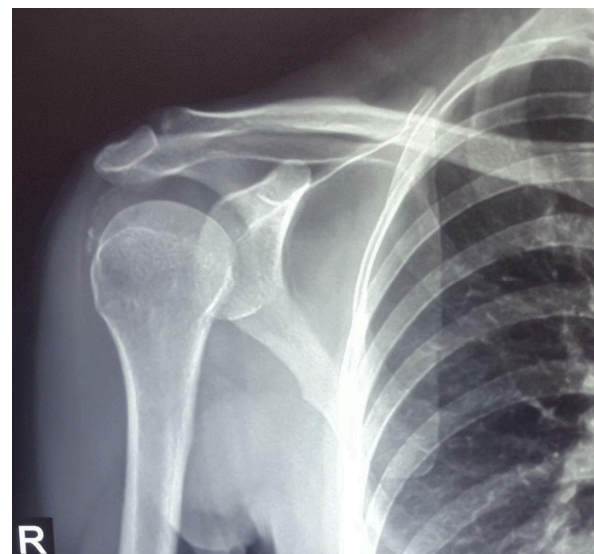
After 5 months anteroposterior shoulder x-ray for the first time was taken and calcify tendonitis was obviously seen
